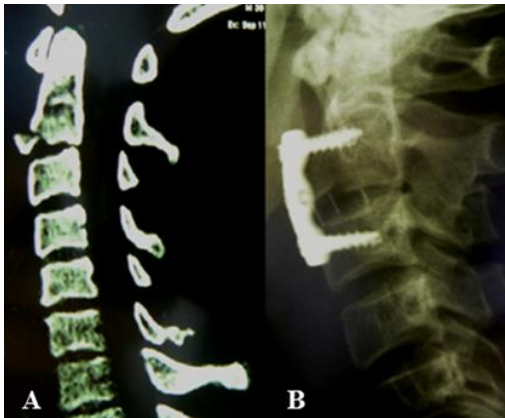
Teardrop fracture of C₂: A/ CT reconstruction; B/ postoperative (X-ray) anterior stabilization
